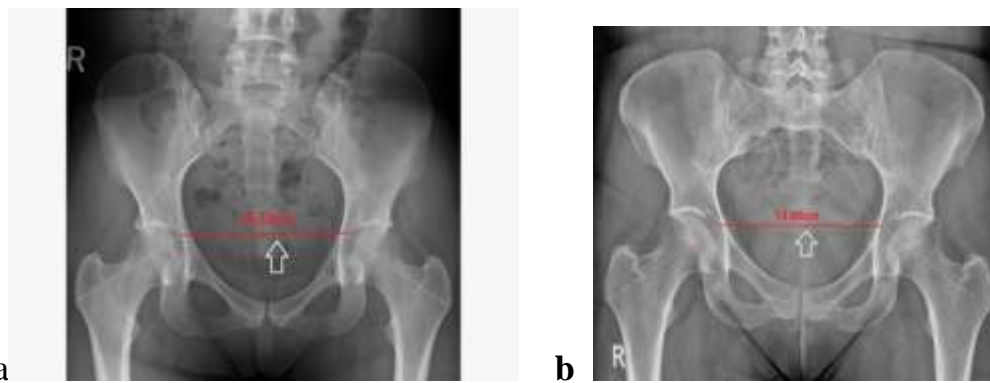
Pelvic bone X-ray (anteroposterior view) showing a greater increase of the interacetabular distance (red line) in the male pelvis (a) than the female pelvis (b).
